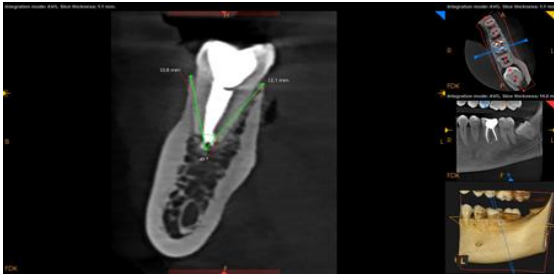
Pre-operative CBCT scan showing the measurement of lingual bone height from the root apex in the mandibular posterior region
